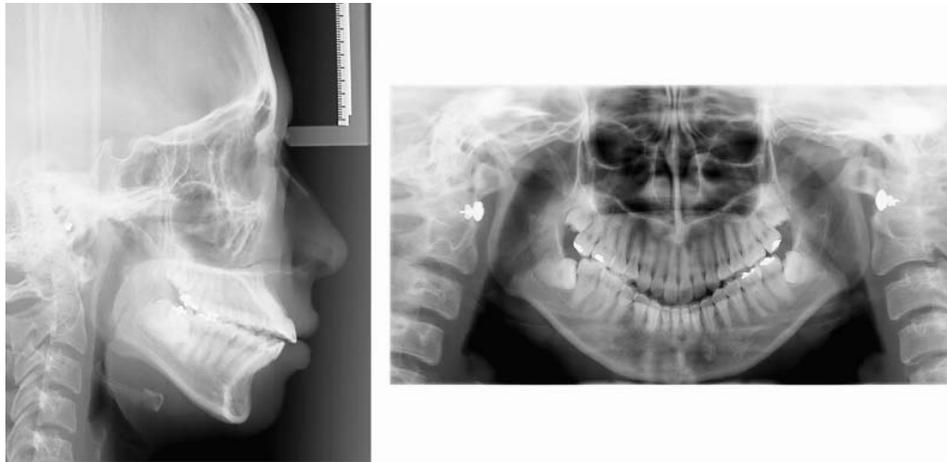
Pretreatment cephalogram and panoramic radiograph.
